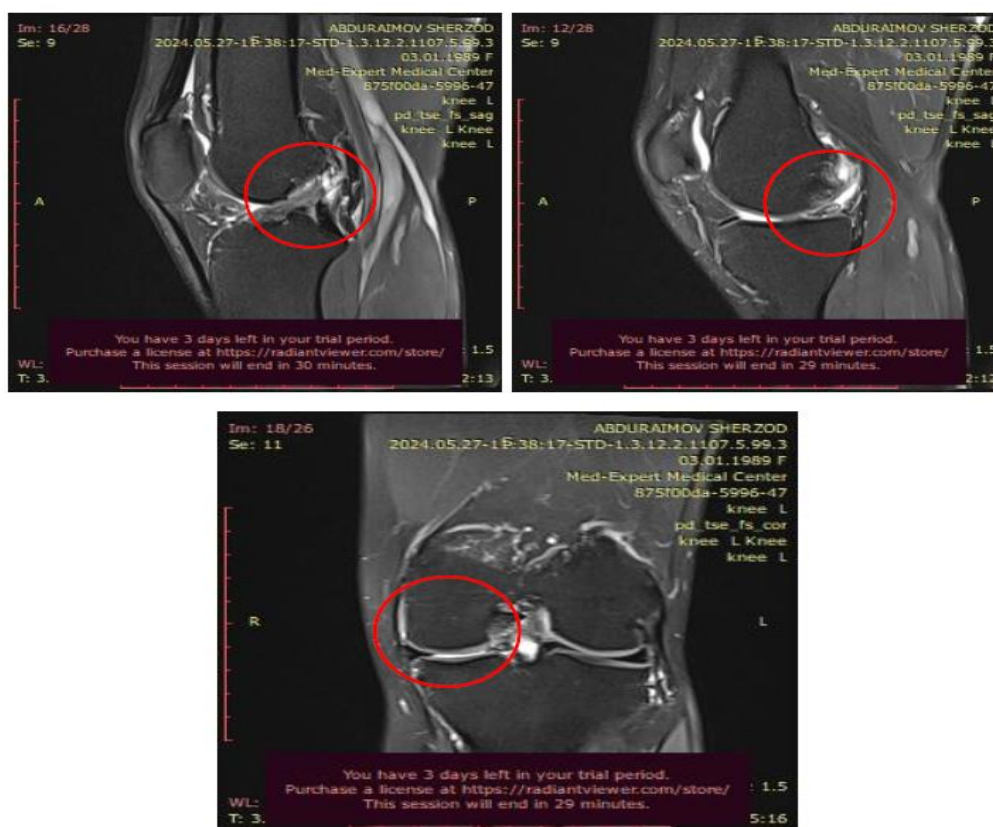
MRI of the knee joint, T1.5, in sagittal and coronal planes.
